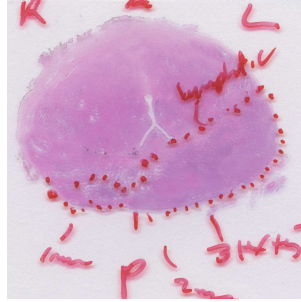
(a) Peripheral zone tumor marked in pathology slide for one patient. (b) Pathology slide registered to the corresponding T2-weighted image. (c) The generated cancer likelihood map superimposed on the T2-weighted image. Note that the classifier is only trained on the peripheral zone. The classifier is trained on all other cases.
